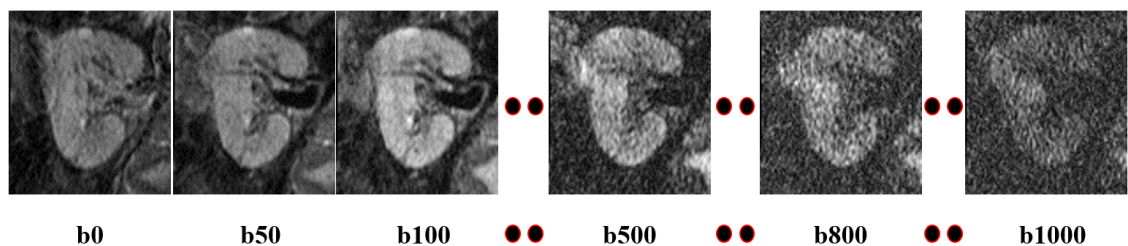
A demonstration of a DW-MRI sequence at different b -values.
